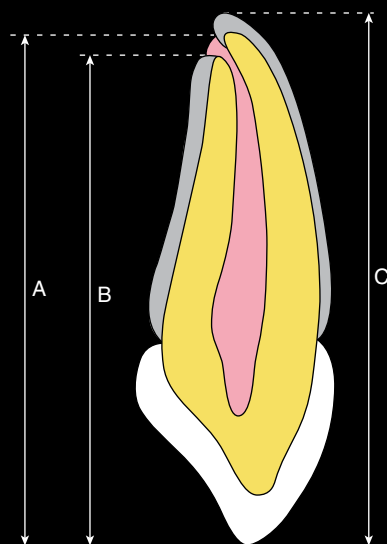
Working length estimation. A = distance from incisal tip to apical foramen, B = distance from incisal tip to apical constriction, C = distance from incisal tip to radiographic apex. The diagnostic radiograph only reveals the position of the radiographic apex. The radiographic apex does not accurately represent the position of the apical constriction or foramen. Therefore it is desirable to use an electronic apex locator.
